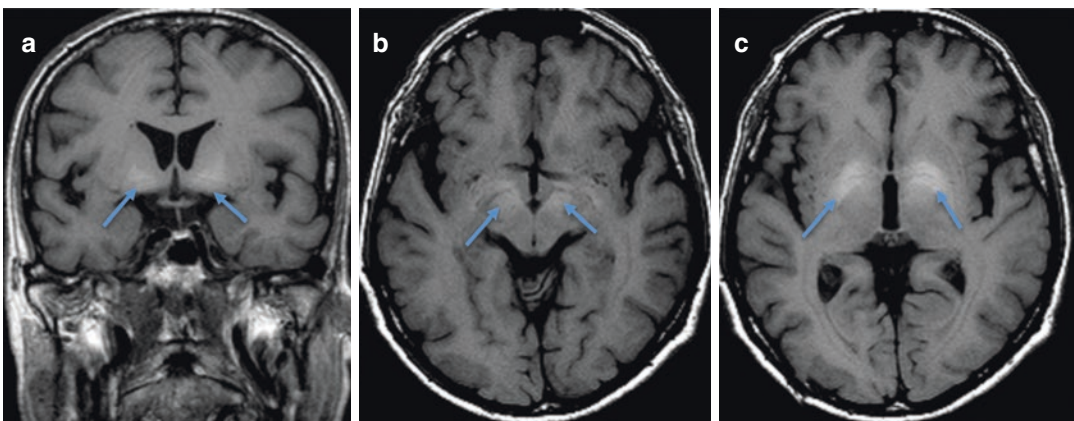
Coronal (a) and axial (b, c) T1-weighted SE images in a 71-year-old man with chronic HE show hyperintense lesions of the innominate substance (a:
